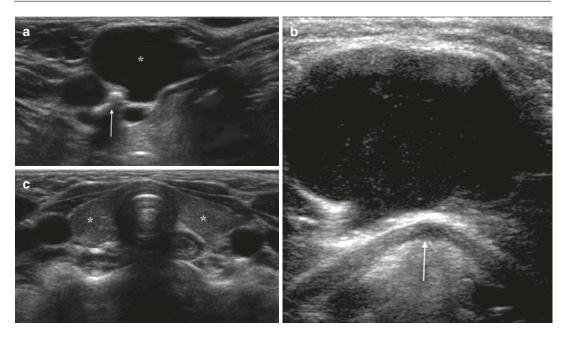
Thyroglossal duct cyst. Longitudinal ultrasound image (a) reveals a midline hypoechoic cystic lesion (*), closely related to the hyoid bone (*arrow*), in keeping with a thyroglossal duct cyst. The transverse
